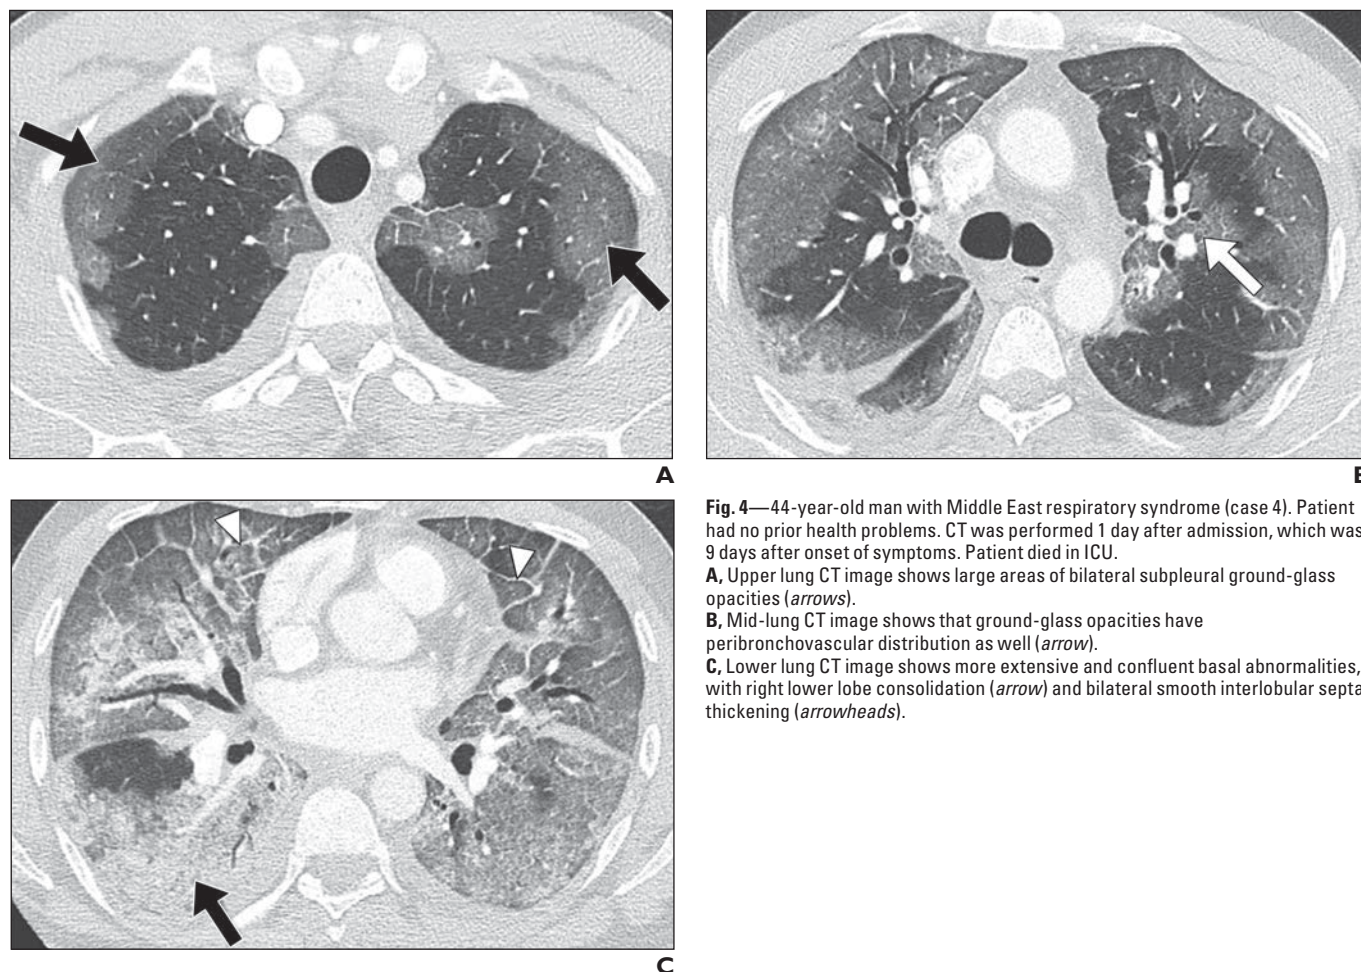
44-year-old man with Middle East respiratory syndrome (case 4). Patient had no prior health problems. CT was performed 1 day after admission, which was 9 days after onset of symptoms. Patient died in ICU.
